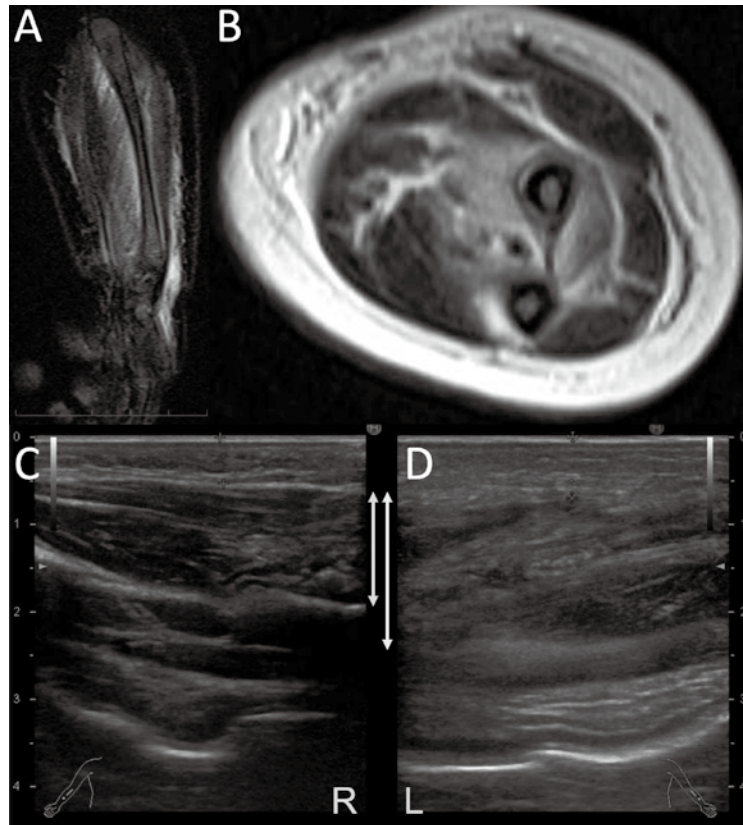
Magnetic resonance imaging (MRI) and ultrasonography (US) images of the patient's left forearm. (A) Contrast-enhanced MRI of the left forearm using T1-weighted sagittal imaging. (B) Contrast-enhanced MRI of the left forearm using T2-weighted coronal imaging. (C, D) US imaging of the right (C) and left (D) forearm
